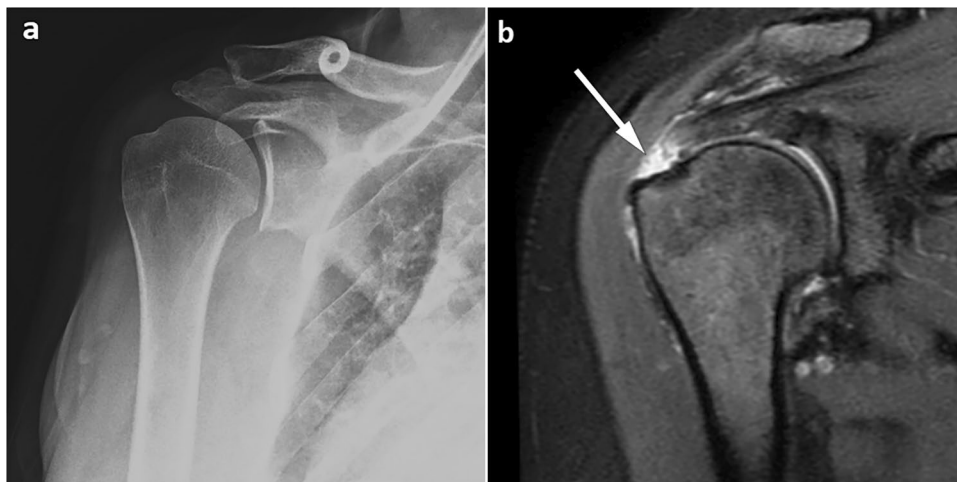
a, b Preoperative radiography and MRI of a 55-year-old female patient. On proton density fat saturation image in the coronal plane, full-thickness supraspinatus tear (white arrow)
